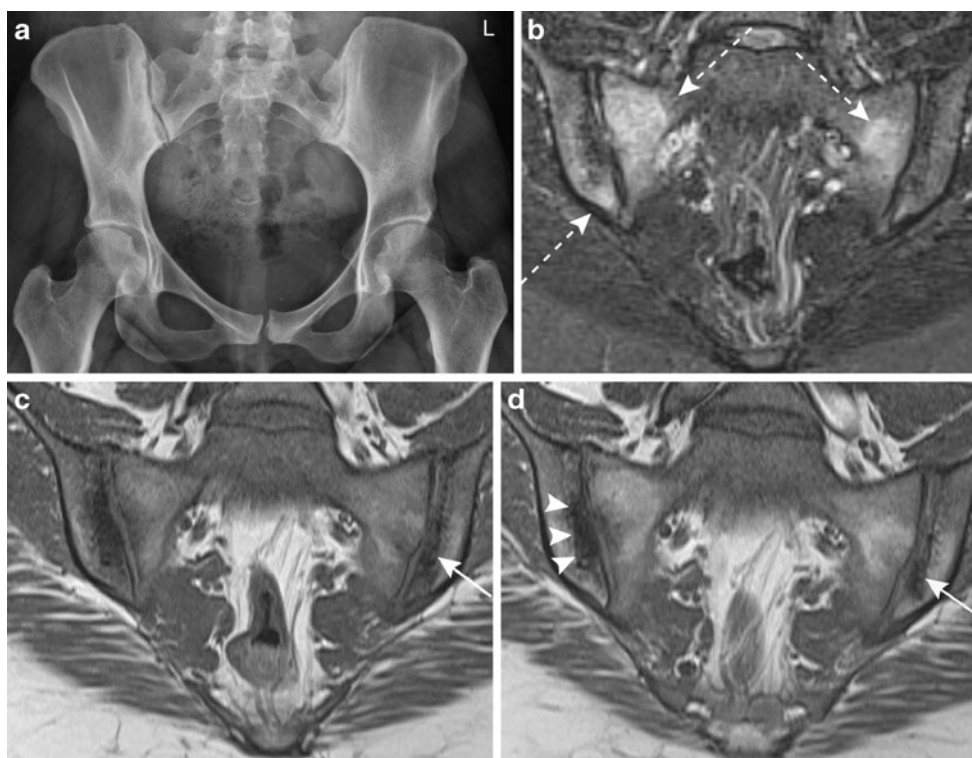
MRI to confirm a diagnosis of preradiographic spondyloarthritis. A 27-year-old, HLA-B27-negative female patient with inflammatory back pain since 19 months. a Pelvic radiograph. The radiographic modified New York criteria are not met. b MRI of the sacroiliac joints, STIR sequence. Bone marrow edema shows in the sacral portion of both sacroiliac joints and in the right distal ilium (*broken arrows*). c MRI of the sacroiliac joints, T1SE sequence. A small erosion is seen in the distal iliac part of the left sacroiliac joint
